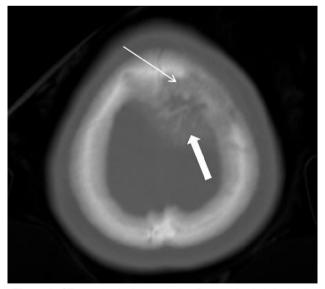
CT scan brain, bone window.Permeative lytic lesion in left frontal bone (thin arrow).Associated soft tissue mass and internal calcification (thick arrow).
